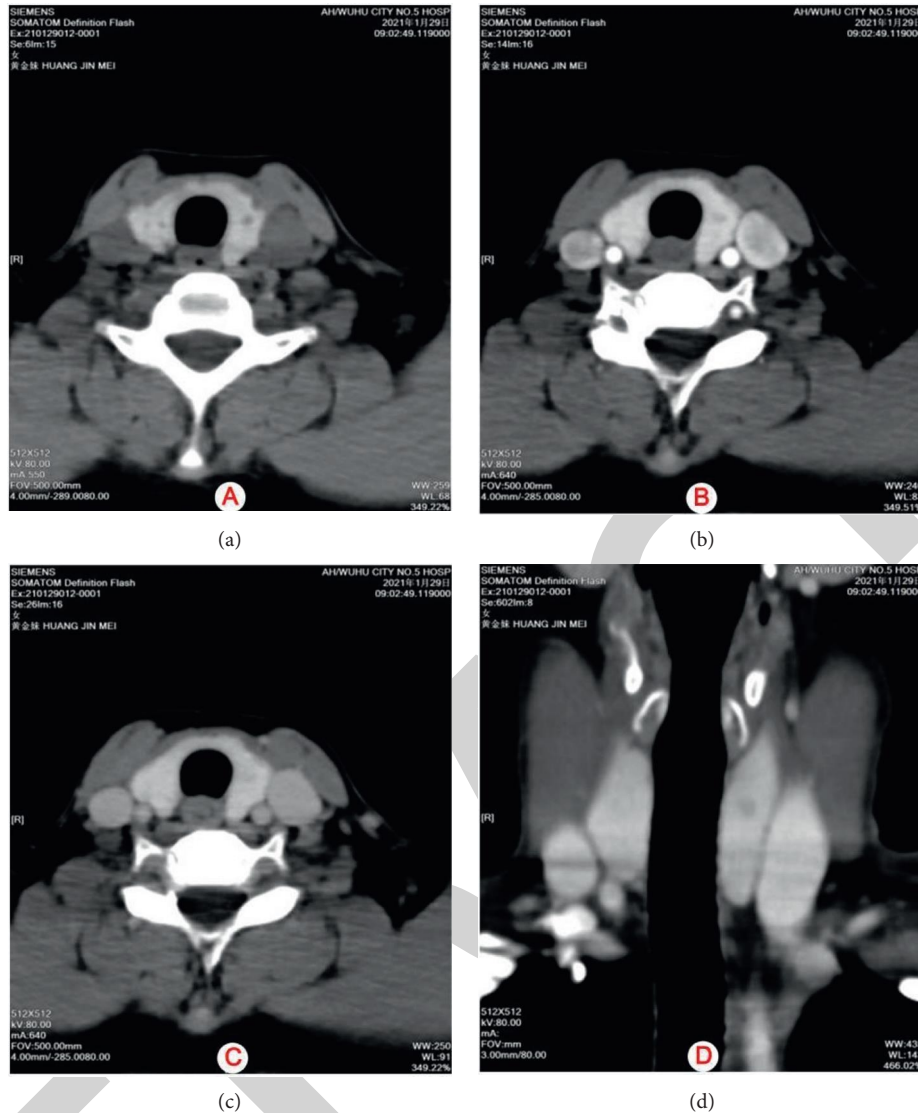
(a)–(d) is plain scan image, arterial phase image, venous phase image, and coronal MPR reconstruction of the thyroid gland image, respectively. Patient information: A 43-year-old female was admitted to the hospital with a left-sided thyroid mass found on physical examination for over 1 month. The thyroid ultrasound suggested a nodule in the left lobe of the thyroid gland with TI-RADS class 4a. CT showed a small nodular hypointense shadow in the left lobe of the thyroid gland with a maximum size of about 4.3×3.9 mm, which was progressively and significantly enhanced and was slightly hypointense compared with the surrounding normally enhanced thyroid gland, with indistinct demarcation. Postoperative pathology confirmed that the nodule was a papillary thyroid carcinoma.
